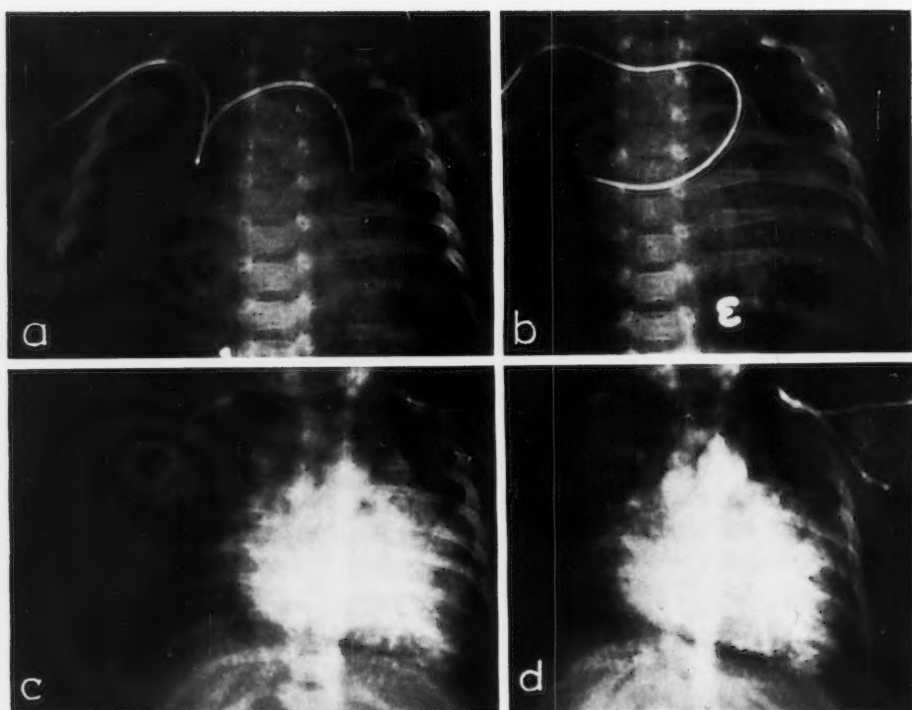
Roentgenograms made at cardiac catheterization (*a* and *b*) and during angiocardiology (*c* and *d*) in infant with total anomalous pulmonary venous drainage into innominate vein (case 2). The cardiac catheter in (*a*) enters the superior vena cava, left innominate vein, and vertical pulmonary vein and in (*b*) enters the right pulmonary vein. Angiocardiology (*c* and *d*) outlines the superior mediastinal course of drainage of pulmonary venous blood.
